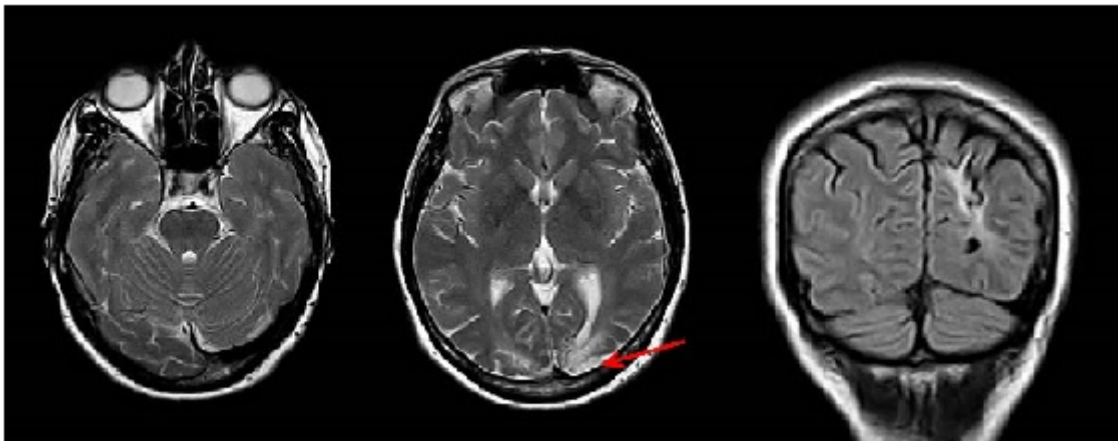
Brain MRI imaging. T2 and coronal FLAIR sequences, showing area of ulegyria involving the left occipital lobe.
